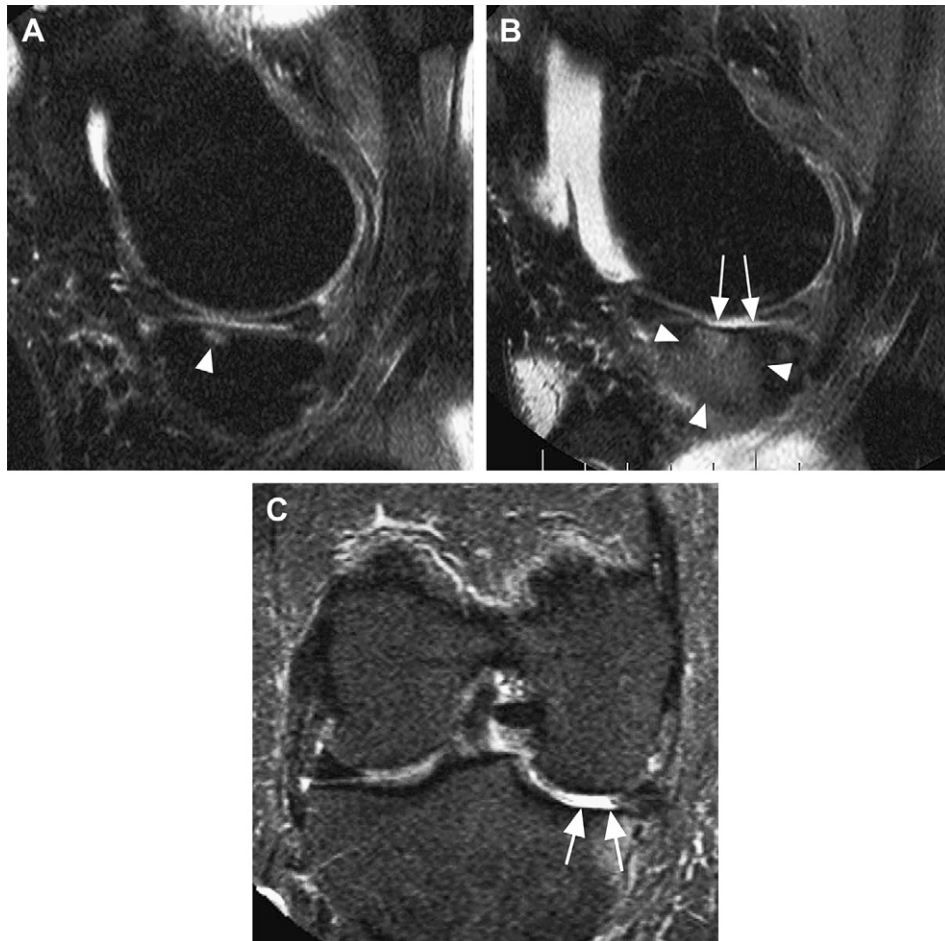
Incident SBA in the medial TF compartment. (A). Sagittal fs PDw MRI at baseline depicts bone marrow lesion in the central subregion of the medial tibial plateau (arrowhead). No attrition is observed. (B). Sagittal fs PDw MRI at 30-months follow-up, demonstrates incident grade 2 attrition in the central subregion of the medial tibial plateau (arrows). Bone marrow lesion has progressed markedly in size (arrowheads). (C). Corresponding coronal STIR MRI also shows attrition, visualized as depression of the medial tibial plateau (arrows).
